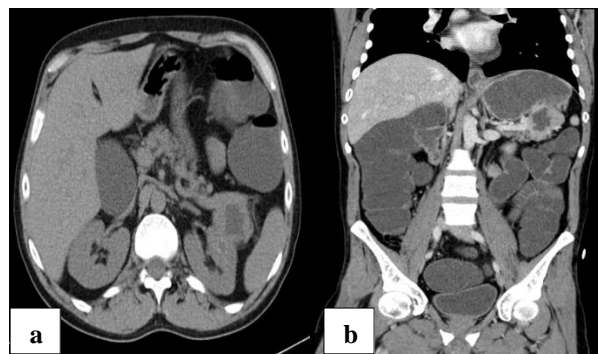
(a) and (b) Contrast-enhanced computed tomography (CT) scan showing a nodular structure in pancreatic tail (axial and coronal section, respectively).
